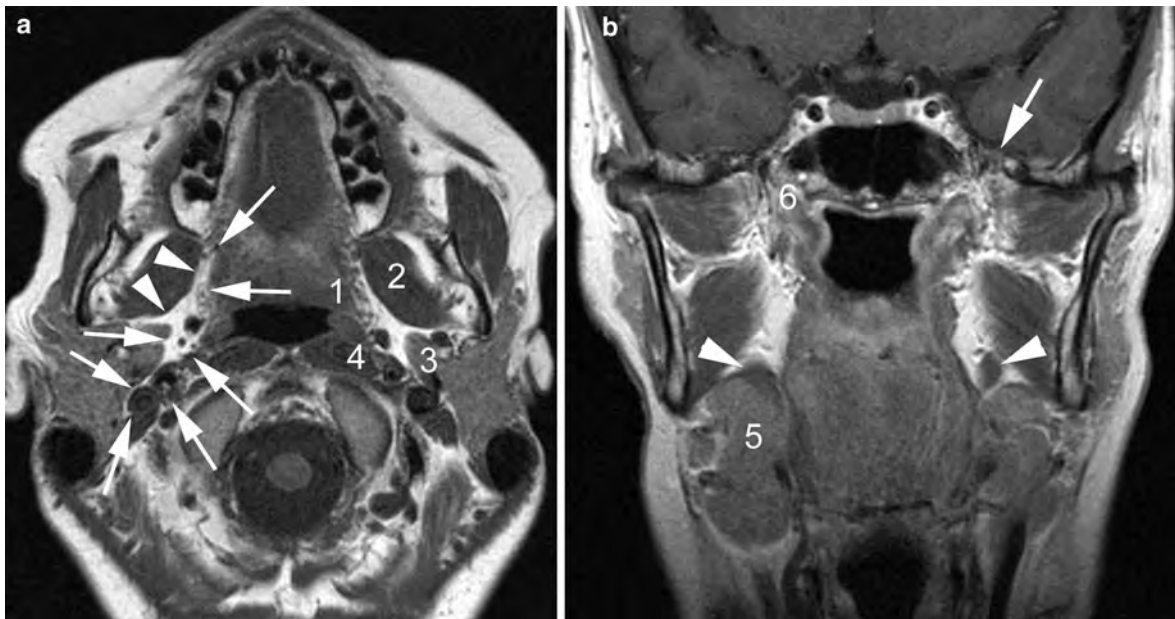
a Axial T1-weighted spin echo image at the level of the soft palate. The boundaries of the parapharyngeal space (PPS) (including prestyloid and retrostyloid compartment) are indicated by *arrows* and *arrowheads* on the *right*. On the *left*, the adjacent spaces are labeled: pharyngeal mucosal space (1), masticator space (2), parotid space (3), retropharyngeal/prevertebral space (4). b Coronal T1-weighted spin echo images
